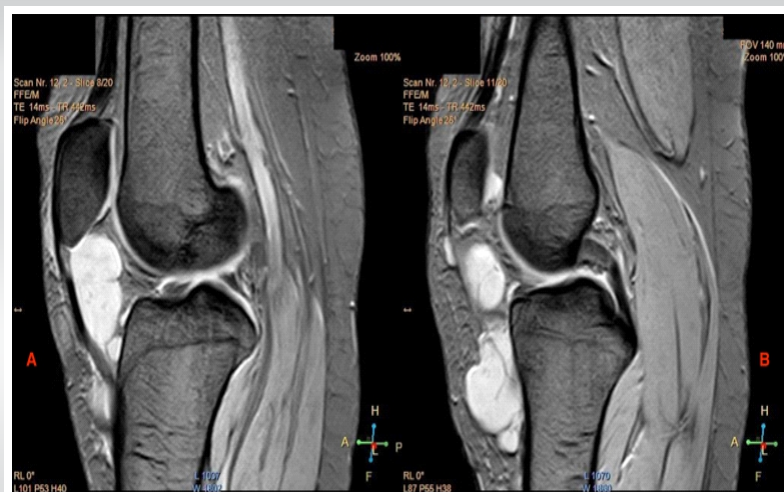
Magnetic resonance imaging of the knee (sagittal) showing the lesion. A T2-weighted proton density fat-saturated image of the left knee reveals a distinct, well-circumscribed juxta-articular multilobulated lesion within the infrapatellar fat pad, measuring approximately $6.7 \times 5.5 \times 2.5$ cm (a), extending inferiorly to the pretibial fat (b).
